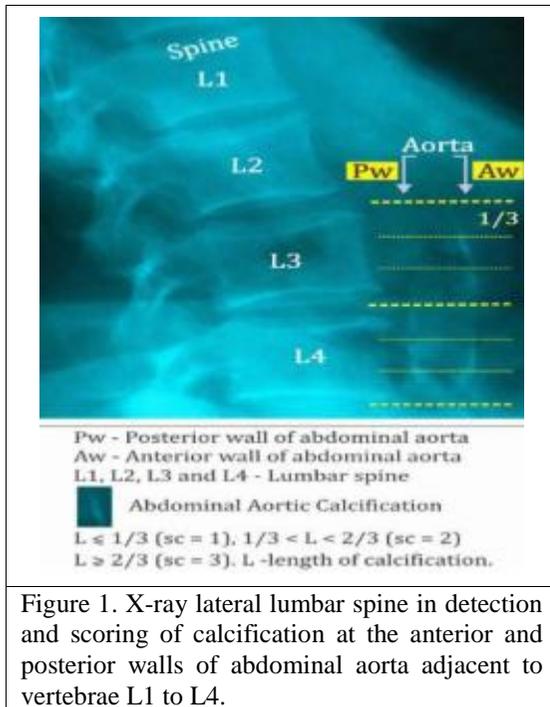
X-ray lateral lumbar spine in detection and scoring of calcification at the anterior and posterior walls of abdominal aorta adjacent to vertebrae L1 to L4.
